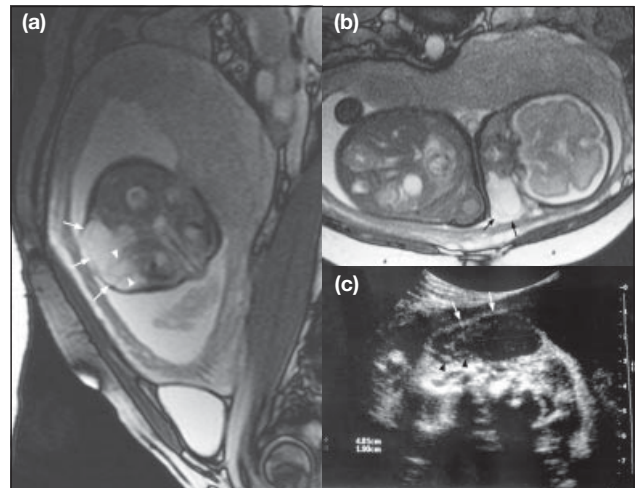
(a) Axial true fast imaging with steady state precession (FISP) image showing a cystic structure (arrows) with internal septation (arrow heads) representing a hygroma located in the left foetal neck. (b) Coronal true FISP image of the foetal neck confirming the presence of the cystic hygroma (arrows) in the left foetal neck. (c) Ultrasonography of the same foetus showing the cystic mass (arrows) with internal echoes (arrow heads) in the left foetal neck
